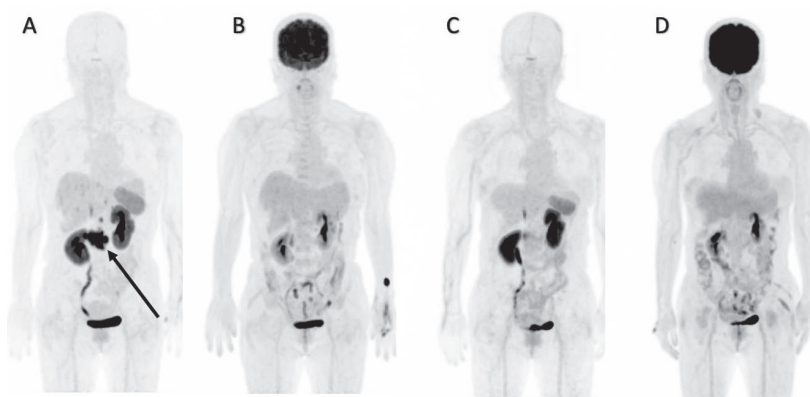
A 66-year-old female patient with a pancreatic head neuroendocrine tumor (NET), staged as cT4N1M0, Stage III, Grade 1, with multiple liver metastases. The patient underwent four cycles of ^{177}Lu -DOTATATE treatment. Post-treatment imaging revealed a significant reduction in tumor burden, with effective control of the primary tumor lesion and stable therapeutic outcomes. (A) Pre-treatment ^{68}Ga -DOTATATE PET/CT showing somatostatin receptor (SSTR)-positive disease (arrow). (B) Pre-treatment FDG PET/CT. (C) Post-treatment ^{68}Ga -DOTATATE PET/CT showing resolution of lesions. (D) Post-treatment FDG PET/CT.
